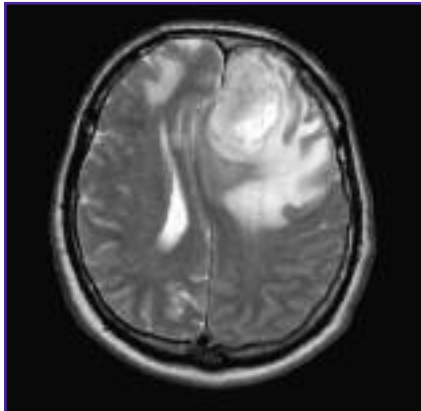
MRI brain showing left frontal mass lesion with edema and midline shift.
